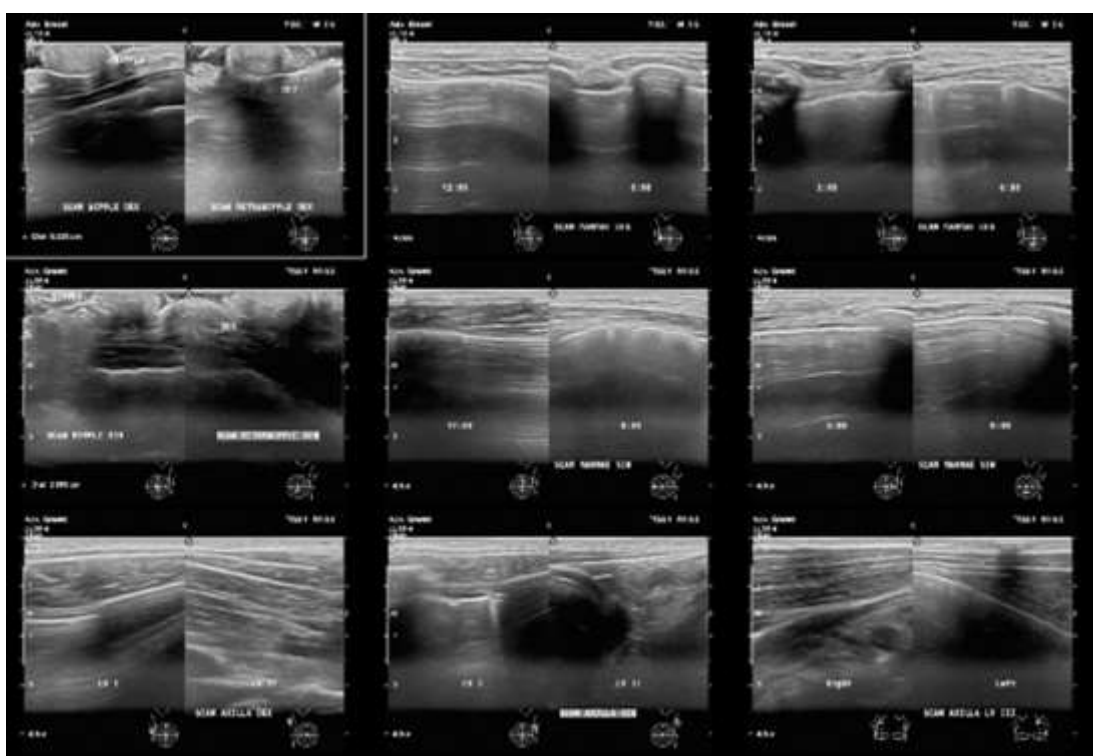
Results of mammary ultrasound.
